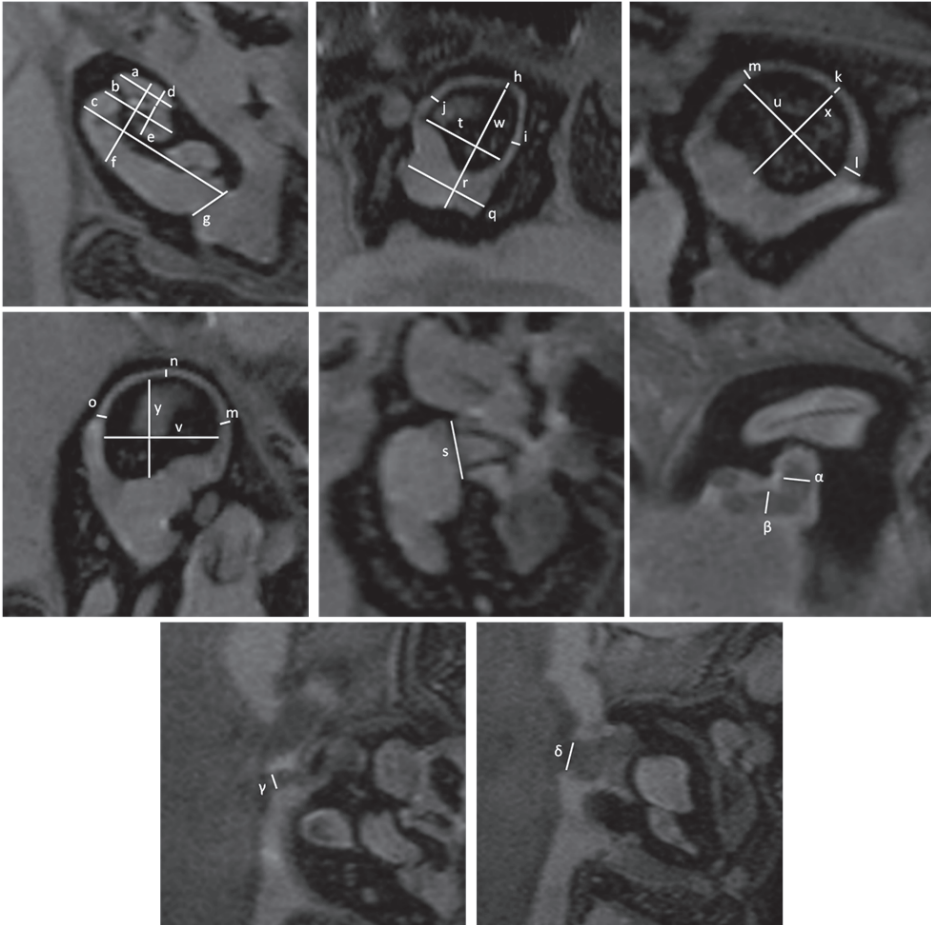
Multiplanar reconstruction of T2-weighted MR scans of detailed structures of the inner ear with markers of measurements. The length of the apical (a), middle (b) and basal (c) cochlear turn occurred in the slice with maximal length of these turns. In the same slice the width of the apical (d) and middle (e) turn and length of the modiolus (f) were measured perpendicularly, as well as the diameter of the round window (g). The measurements of the semicircular canals were made in slices along the long axis of the canal (double oblique). The diameter of the lateral semicircular canal was measured at the apex (h), at the centre of the anterior (i) and posterior (j) limb. In the same slice the vestibular width (q) and length (r) were derived. The diameter of the posterior semicircular canal was measured at the apex (k), just above the common crus at the medial limb (l) and at the same height at the lateral limb (m). The diameter of the superior semicircular canal was measured at the top (n), just above the common crus at the posterior limb (o) and at the same height at the anterior limb (p). The measurement of width (t,u,v) and length (w,x,y) of the bony islands were made perpendicularly in the same slides. The diameter of the oval window (s) was taken in a slide parallel to the slide of the cochlear turns. The diameter of the cochlear and inferior vestibular nerve (α) together and the superior vestibular nerve (β) were taken in a perpendicular view, at the outlet from the modiolus. The measurement of the facial nerve (γ) and vestibulocochlear nerve (δ) were made just after the root entry zone in a coronal view.
